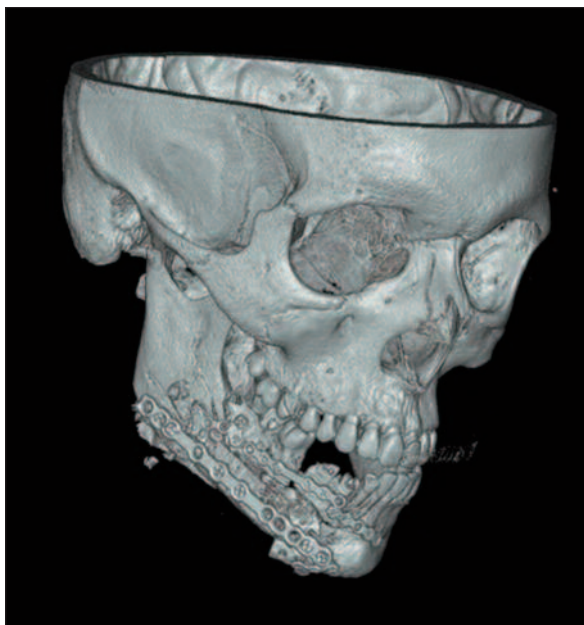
It can be seen that the osseous structure in normal in the control CT at 6 months in the patient demonstrated in Figures 1 and 2.
